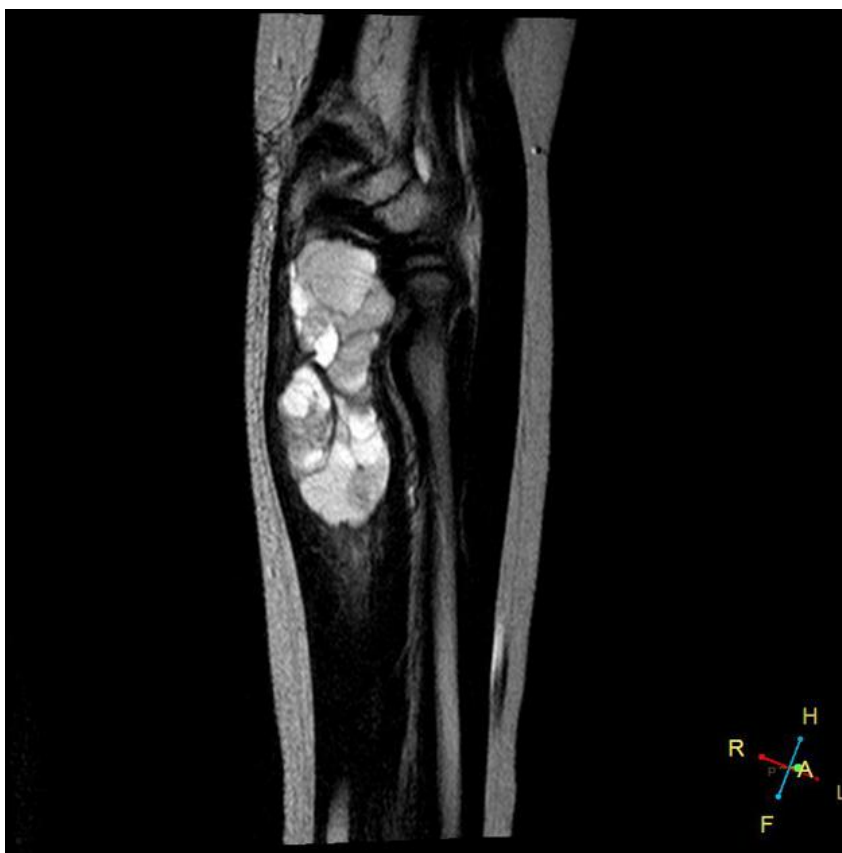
MRI of a 10-year-old female with aneurysmal bone cyst of the left proximal ulna. Sagittal T2-weighted image shows an expansile lesion in the proximal ulnar metadiaphysis with extension to the epiphysis. The lesion displays multiple cysts with fluid/fluid leveling. Image courtesy of Dr. Ahmed Abdrabou. <https://radiopaedia.org/cases/aneurysmal-bone-cyst-8?lang=us>
